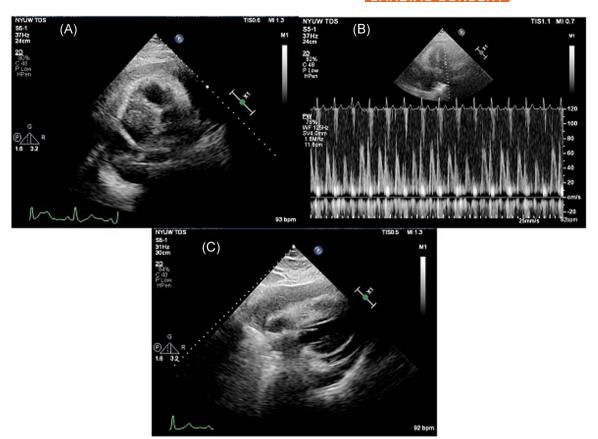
A, Top left, subcostal view: There is a large circumferential pericardial effusion. B, Top right, continuous wave Doppler through the mitral valve in the four chamber apical view: This image shows significant (>30%) respiratory variation in mitral inflow velocity. C, Bottom, subcostal view: There is a large circumferential pericardial effusion with visible partial collapse of the right ventricle and right atrium
